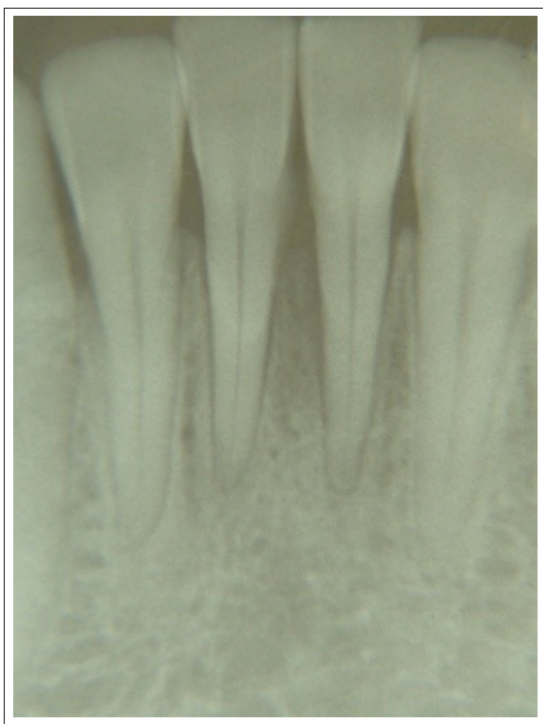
Periapical X-Ray Indicated Calculus Accumulation and Horizontal Bone Loss on Teeth 32, 31, 41 and 42
